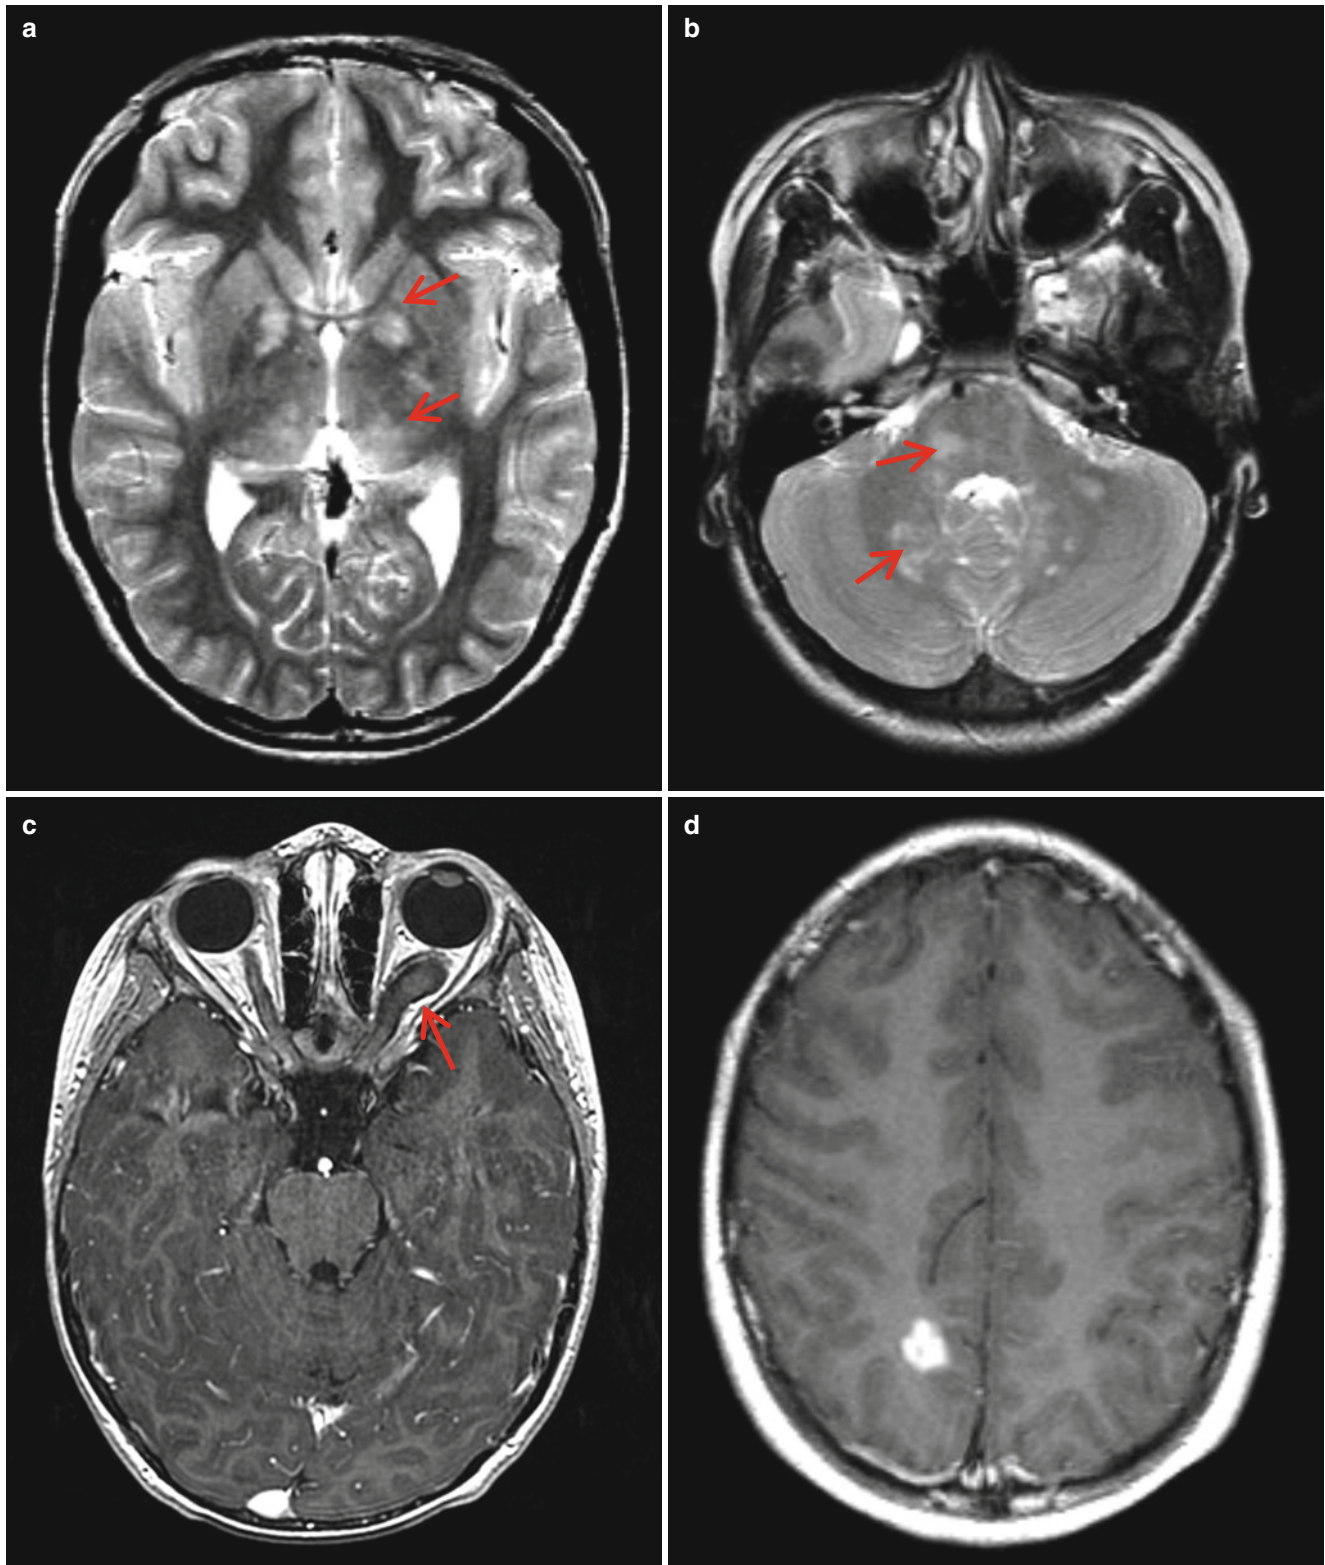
Neurofibromatosis type 1. (a, b) Axial T2-weighted images show multiple nodular high signal intensity lesions (*arrows*) in the globus pallidus, posterior thalami, pons, and cerebellar white matter.
